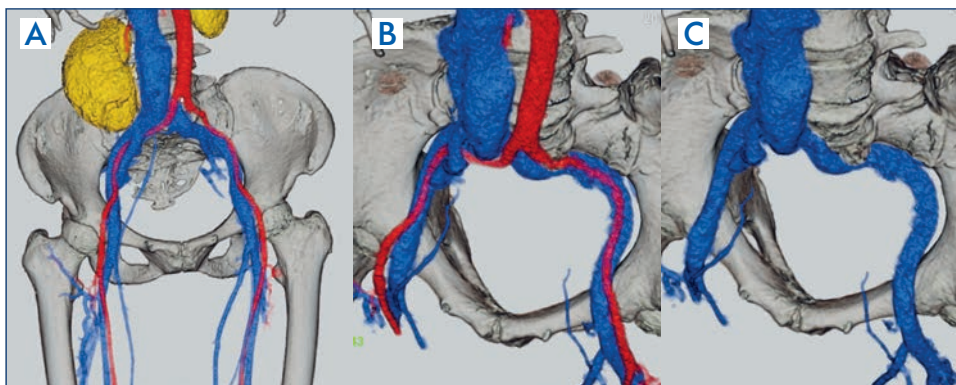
Nonthrombotic iliac vein lesions case: findings from contrast-enhanced computed tomography.
